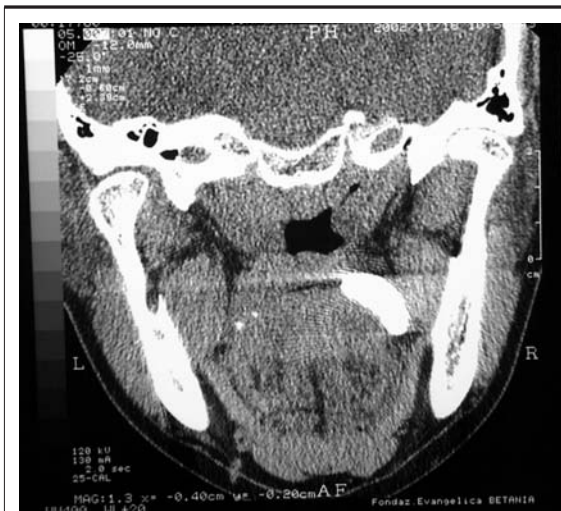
CT scan reveals a hyperdense lesion in the right tonsil.
